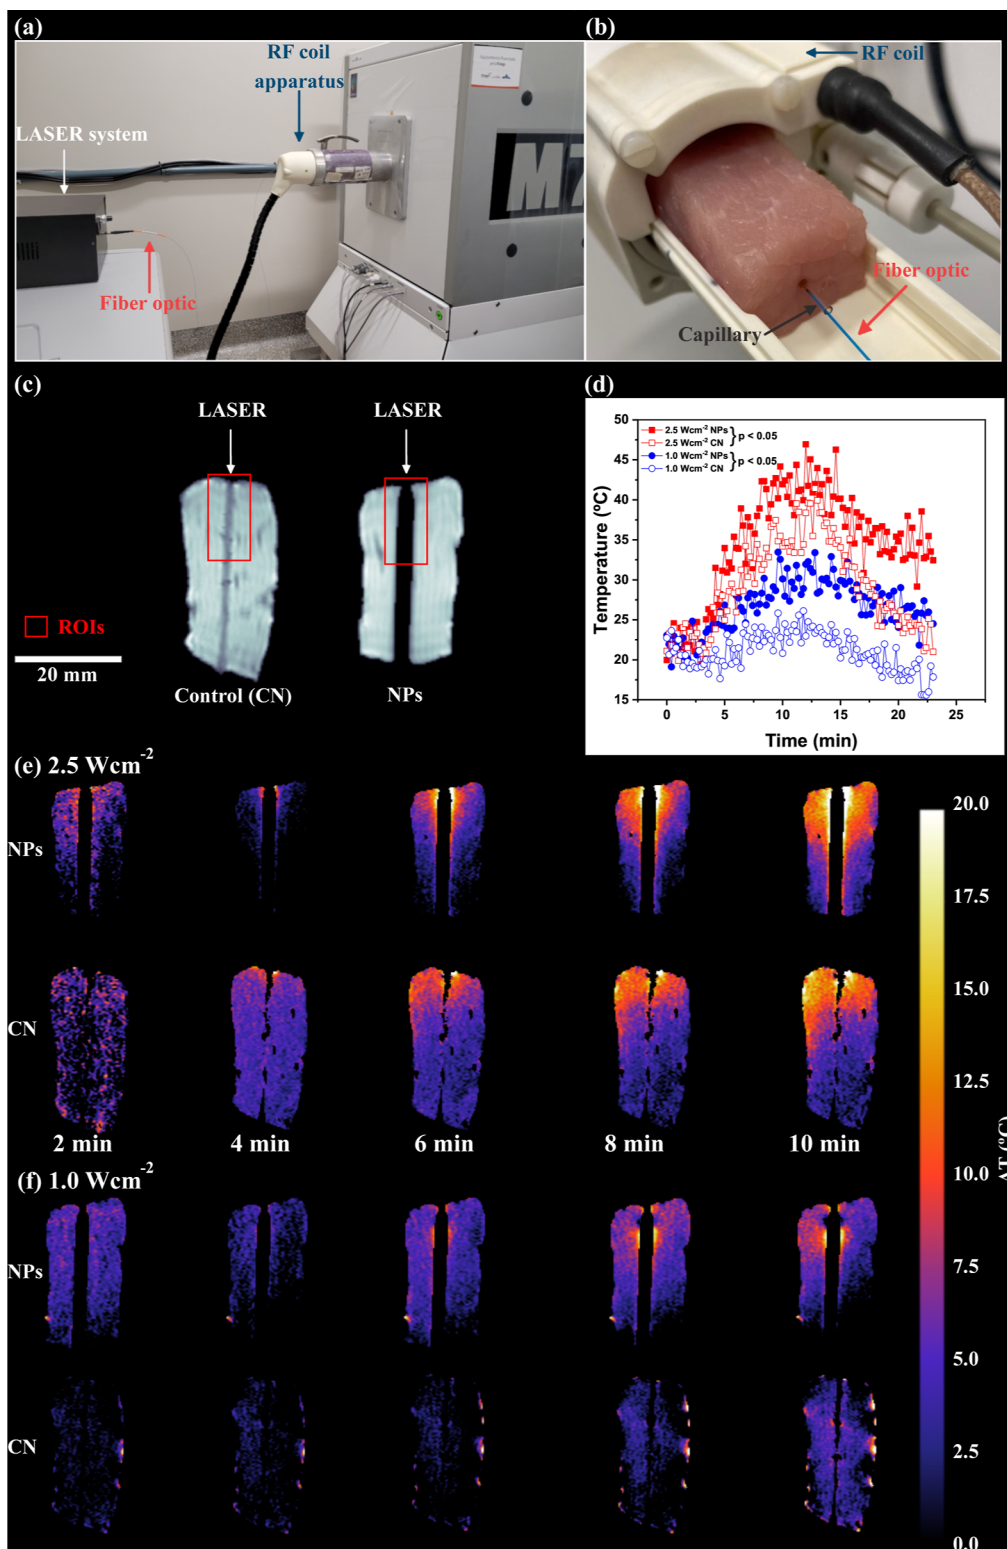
(a) Image of the laser system, fiber optic, RF coil apparatus, and MRI equipment used for PRF thermometry. (b) Close-up view of the RF coil, pork loin, fiber optic, and capillary tube. (c) Reconstructed GRE MRI images of a pork loin with the capillary inserted; on the right, the capillary is filled with 50 μL of water (control—CN), and on the left, it is filled with 50 μg of MnFe_2O_4 NPs. Two ROIs and the fiber optic laser positions are highlighted. (d) Temperature profile during the PTT trial for different laser powers ($2.5 \text{ W}\cdot\text{cm}^{-2}$ and $1.0 \text{ W}\cdot\text{cm}^{-2}$). (e) 2D temperature variation maps obtained via MRI-PRF thermometry at different times during NP-mediated PTT and water-mediated PTT, both at $2.5 \text{ W}\cdot\text{cm}^{-2}$. (f) 2D temperature variation maps at $1.0 \text{ W}\cdot\text{cm}^{-2}$.
